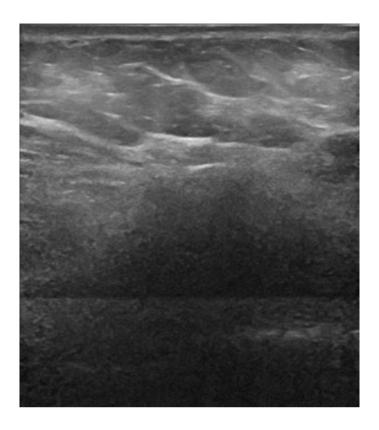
US "Second-Look" corresponded to a hypoechoic, irregular, indistinct mass, no significant flow on color Doppler, of a posterior location that was only possible to be observed in the vicinity of the left anterior axillary line. This case highlights the importance of always looking at the entire breast, which ranges from the infraclavicular region to the inframammary fold and the middle axillary line to the sternal region.
